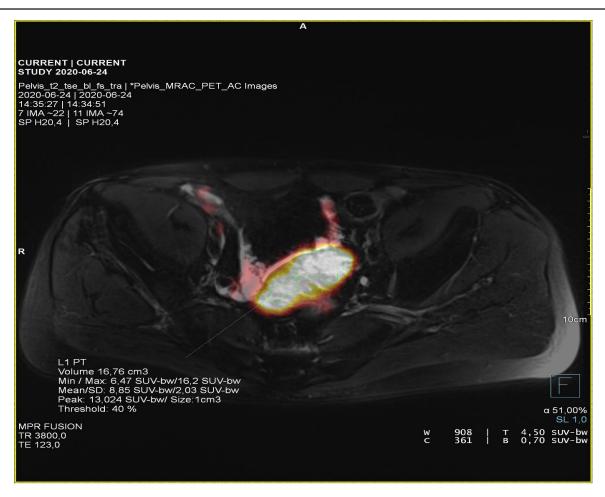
[68Ga] Ga-PSMA PET/MRI scan showing increased radiopharmaceutical uptake.
